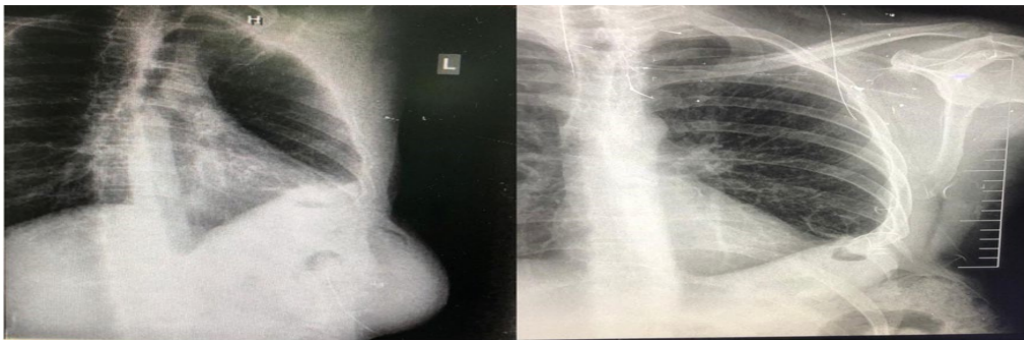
Chest X-ray showing a defect in the left chest wall containing what appears to be bowel loops.
